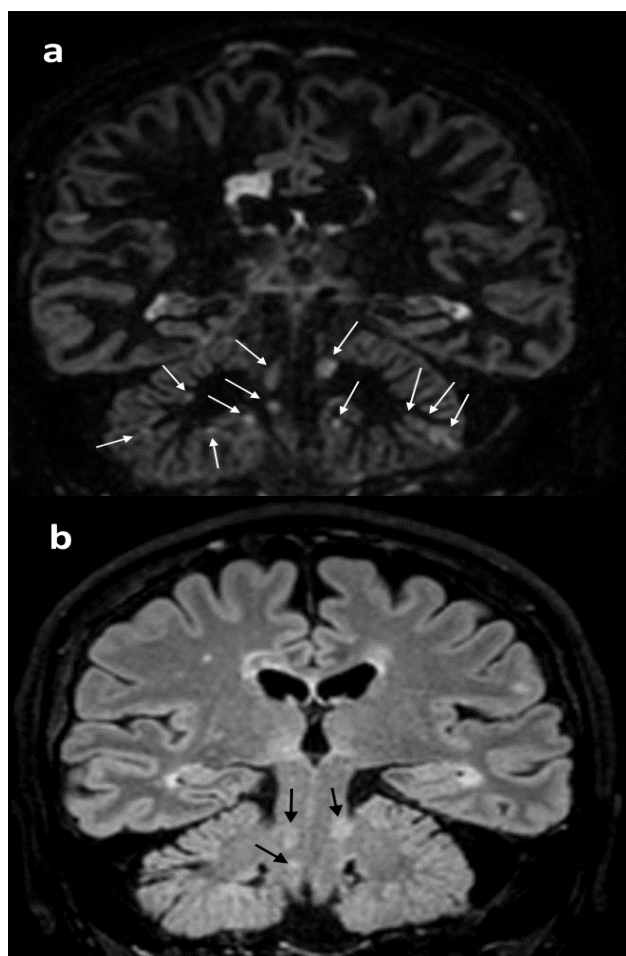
Brain stem and cerebellar lesions are much more numerous and more prominently seen in the coronal DIR image (a) than in the coronal FLAIR image (b)
